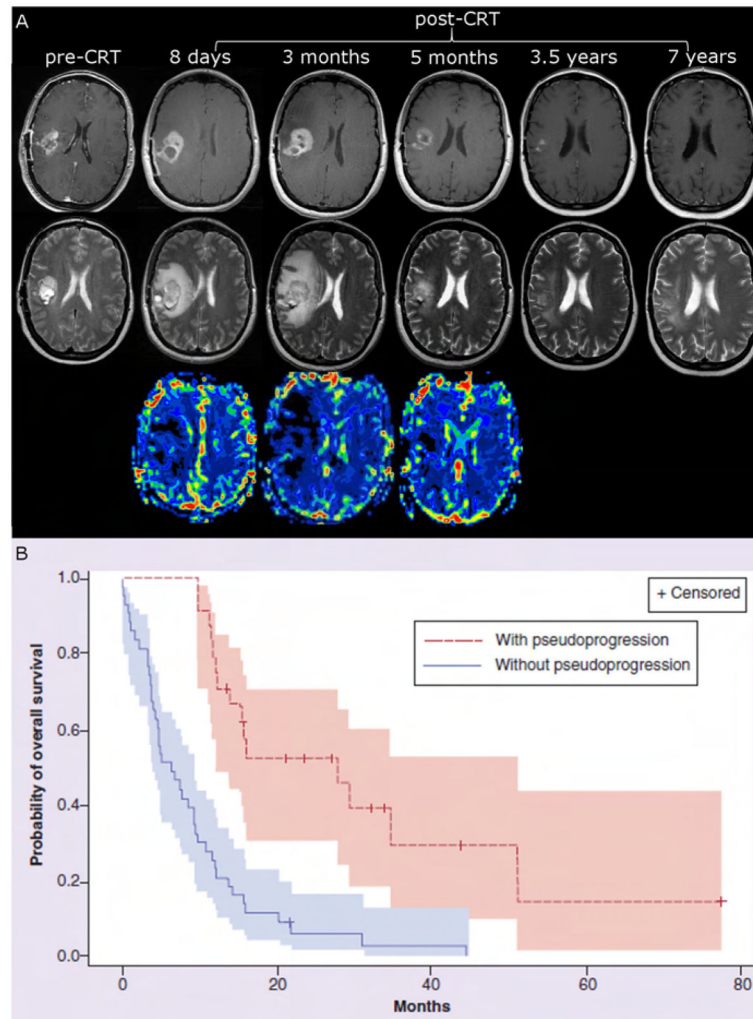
Pseudoprogression can be diagnosed using perfusion MRI with ferumoxytol and correlates with OS.
